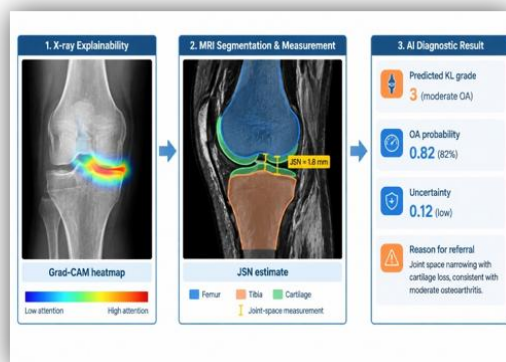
Explainability and measurement output: radiographic attention, MRI anatomical segmentation, JSN estimate, and calibrated diagnostic summary.
